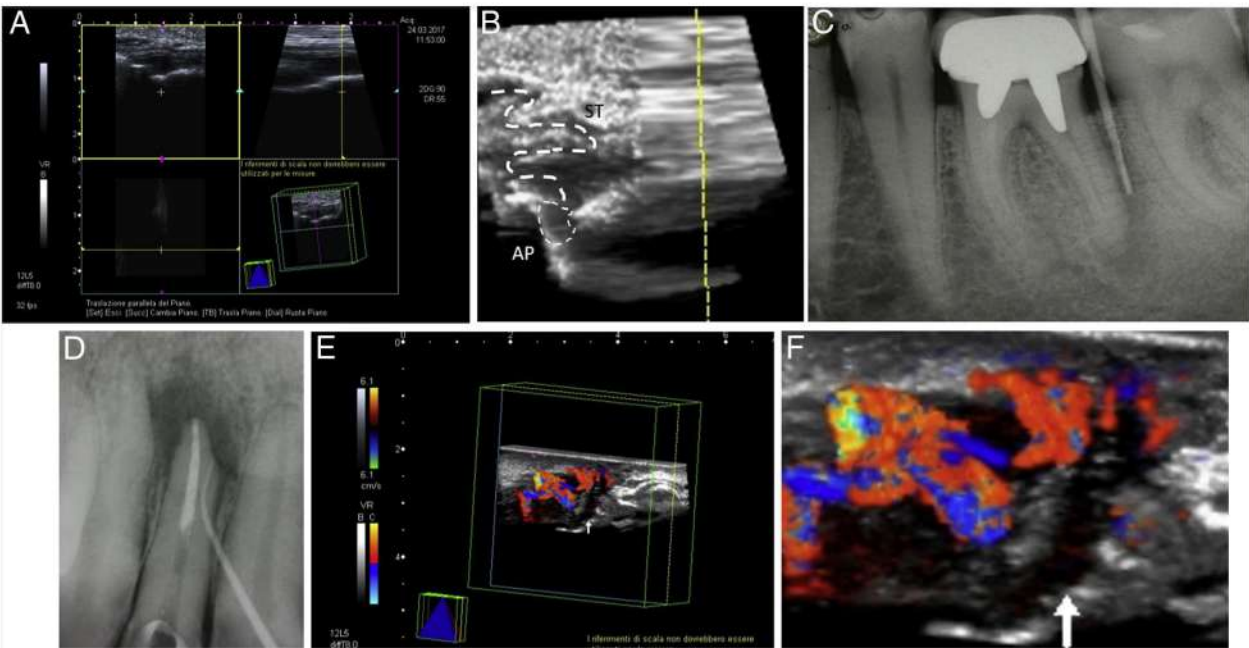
(A) An APST case visualized in the 3D elaboration mode. (B) Tridimensional reconstruction of AP (*interrupted contour*) and the ST (*interrupted line*). (C) A periapical radiograph of the same case and tracing of the tract (tooth #18). (D) An APST case traced with a gutta-percha cone and a periapical radiograph (tooth #7). (E) Evaluation of the vascularity in the same case using CPD. (F) CPD detail showing the ST (*arrow*) and identifying the presence of small vessels at the walls of the ST lumen.
